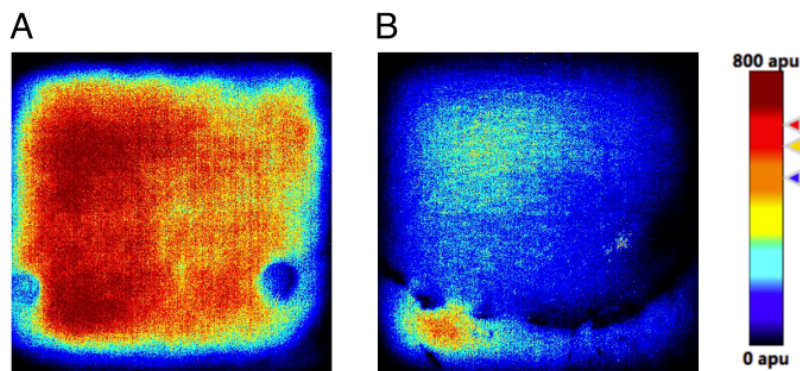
Doppler Images. A: Immediately after LAVA. B: During follow-up after 1 week.
